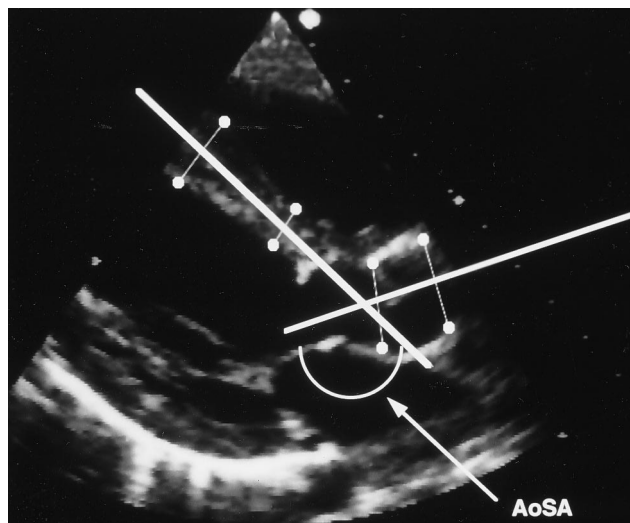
Measurement of the aortoseptal angle (AoSA) from the parasternal long-axis view in early systole (just before aortic valve opening).
